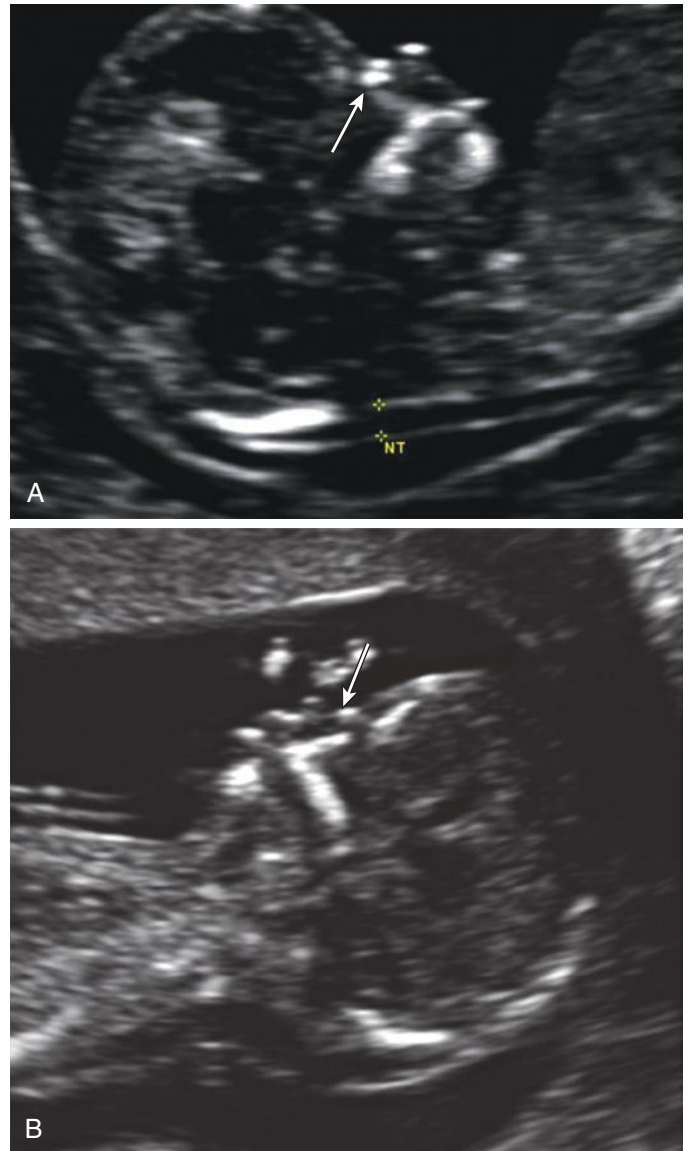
A, First trimester ultrasound examination at 13 weeks' gestation demonstrating the presence of a nasal bone (*arrow*) below and parallel to the overlying skin. B, Absent nasal bone (*arrow*) in a fetus with trisomy 21. The nuchal translucency is also enlarged in this fetus.
